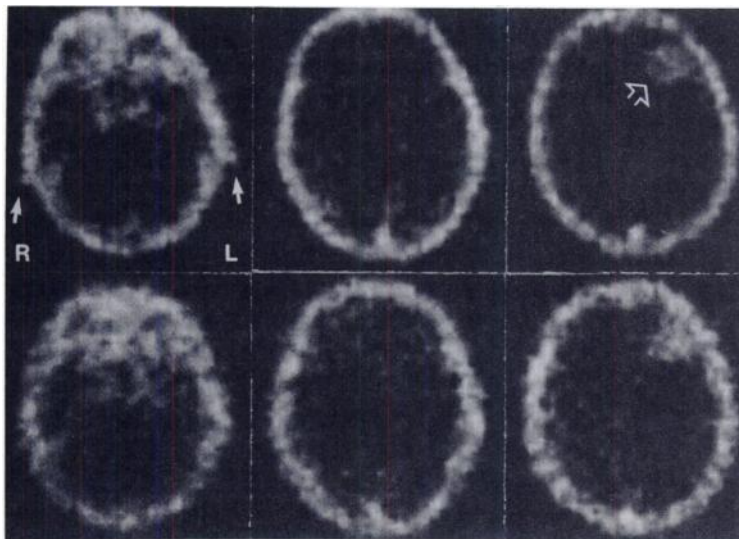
SPECT studies of 76-yr-old female patient with metastasis from adenocarcinoma, performed with a radius of rotation of 12 cm (upper) and 20 cm (lower) after i.v. injection of 13.5 mCi (500 MBq) pertechnetate. Radioactivity in large vessels around sella and in transverse sinus is more easily identified in upper images than in lower. Metastasis (arrowhead) is better separated from surrounding tissues due to higher spatial resolution. Note superior portions of auricles, visible at top left (arrows).
